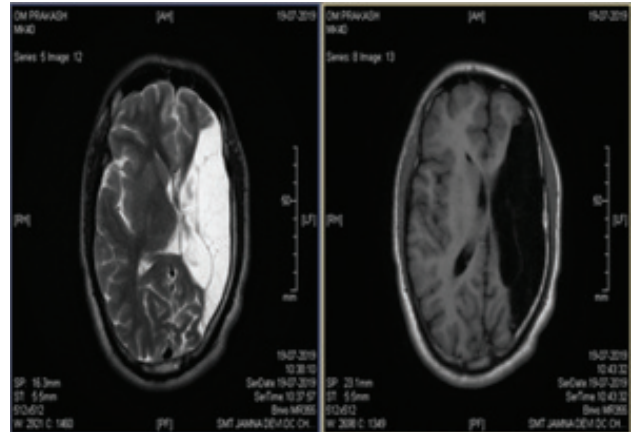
MRI brain showing an area of gliosis of left cerebral hemisphere in T1W and T2W images.
